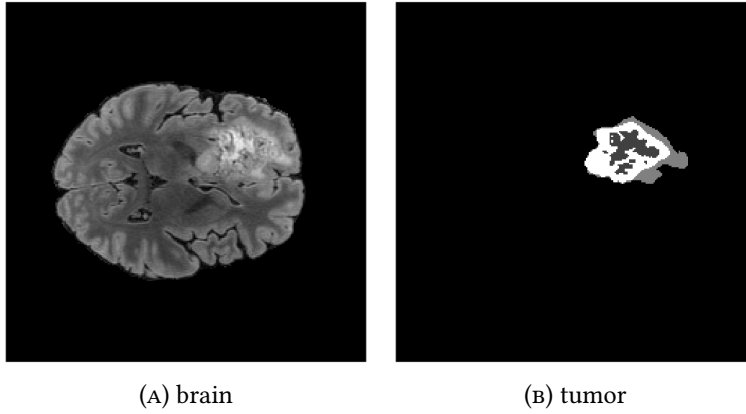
Brain image of FLAIR modality for the adult glioma and the associated tumor region
